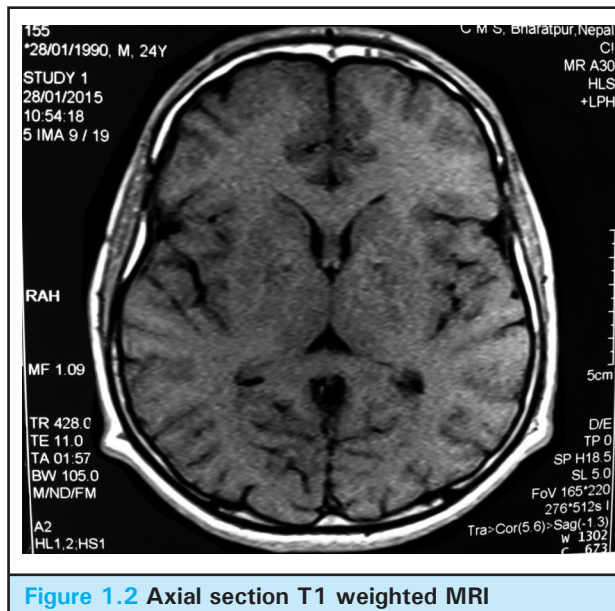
Axial section T1 weighted MRI
